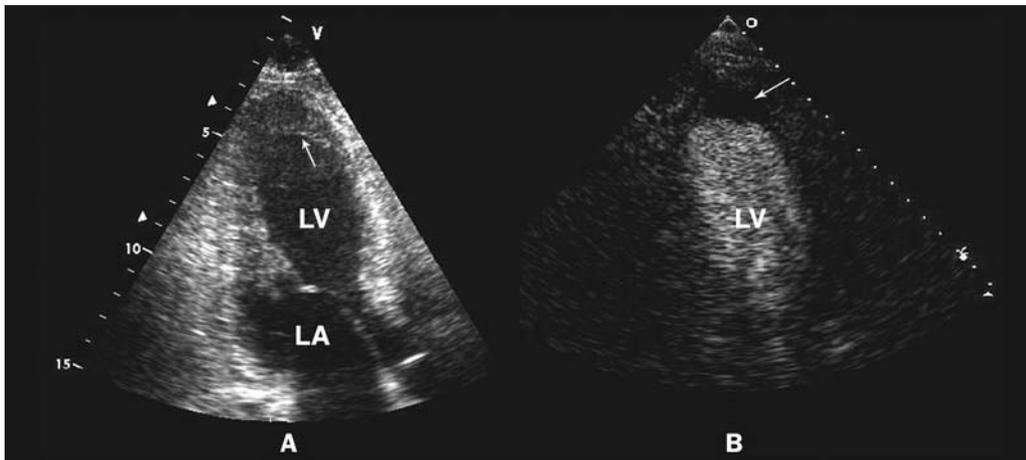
A) Non-contrast two-dimensional transthoracic echocardiogram revealing apical left ventricular thrombus (arrow). B) The addition of LUMINITY (R) contrast clearly defines the borders of the layered left ventricular thrombus (arrow) and confirms absence of mobile elements. LV=left ventricle, LA=left atrium.
